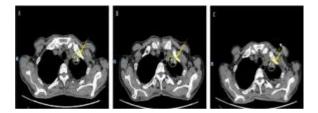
Re-examination of tumor using CT. After 1 year of camrelizumab treatment, the mass in the left upper lung was shrunk (A, 2.2×1.5 cm), and it remained well-controlled after 2 years (B, 2.2×1.4 cm). The last re-examination was on September 14, 2022, 3 years after diagnosis, and the mass in the left upper lung was still in a stable state (C, 2.4×1.5 cm)
